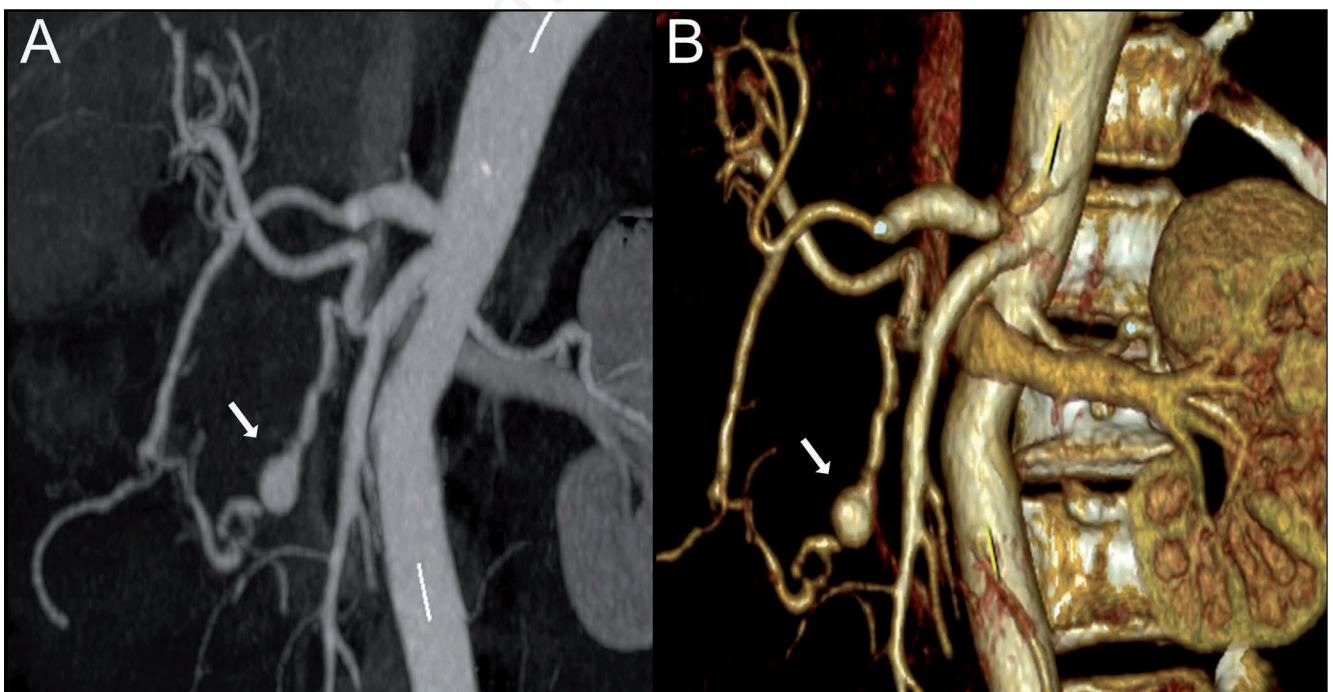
A case of segmental arterial mediolysis. Maximum intensity projection of the arterial phase of the angio-computed tomography (A) and volume rendering (B) showing a typical aneurism of the celiac-mesenteric trunk.
